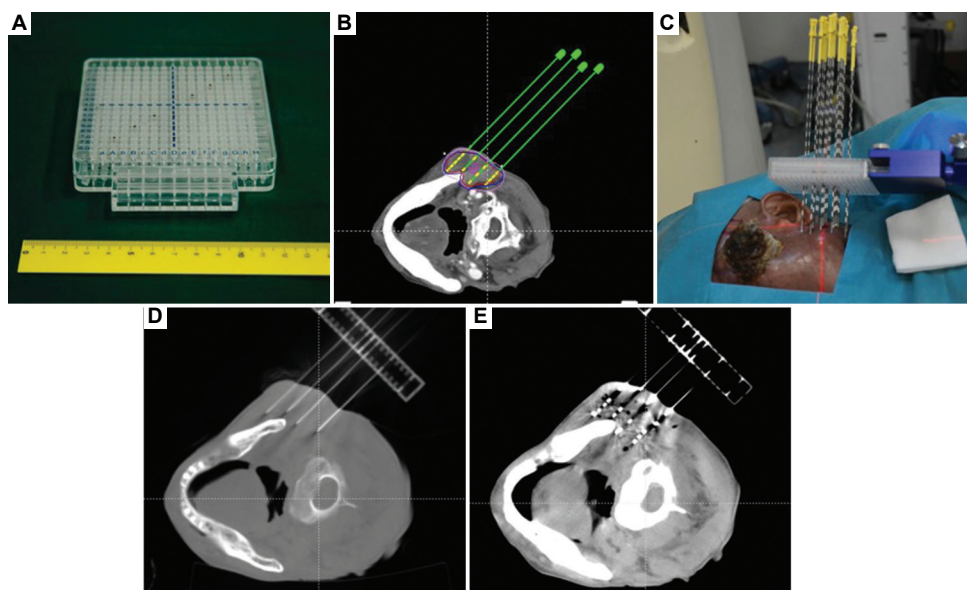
The three-dimensional-printing co-planar template utilized in computed tomography-guided iodine-125 radioactive seed implantation. (A) Print personalized 3D-printing co-planar template through 3D printing. (B) Pre-operative planning design. (C) Insert needles. (D) Verify needle positions. (E) Perform ¹²⁵I seed implantation.
